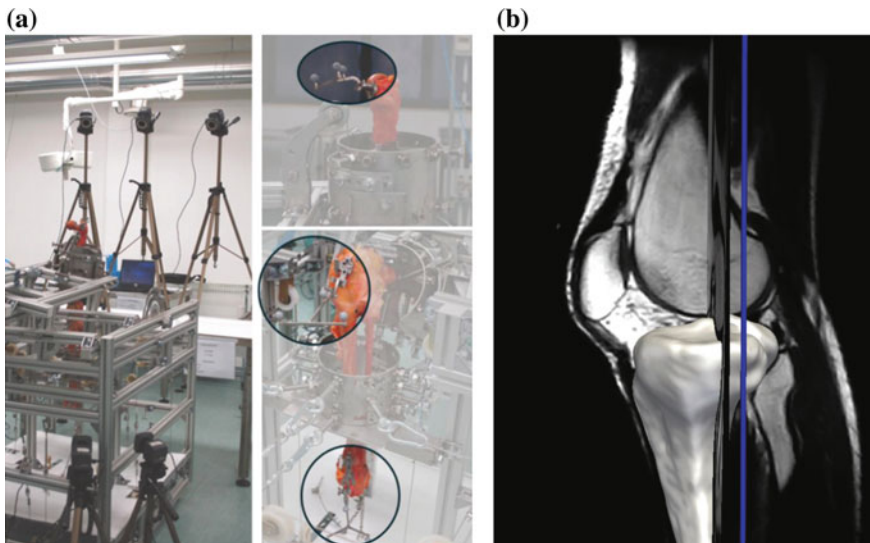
a Stereophotogrammetric system for the measure of the bone relative motion. b Reconstruction of knee anatomy from MRI
